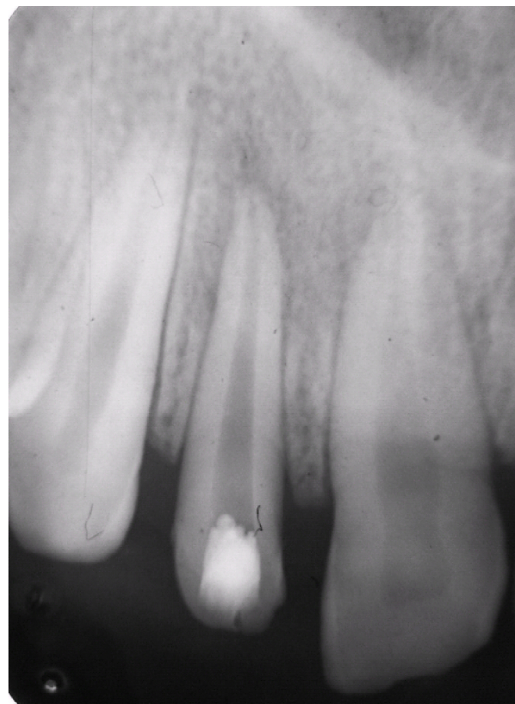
Follow-up radiograph after 4 months showing reduction in periapical radiolucency and sign of apical closure which indicates periapical healing in progress.
